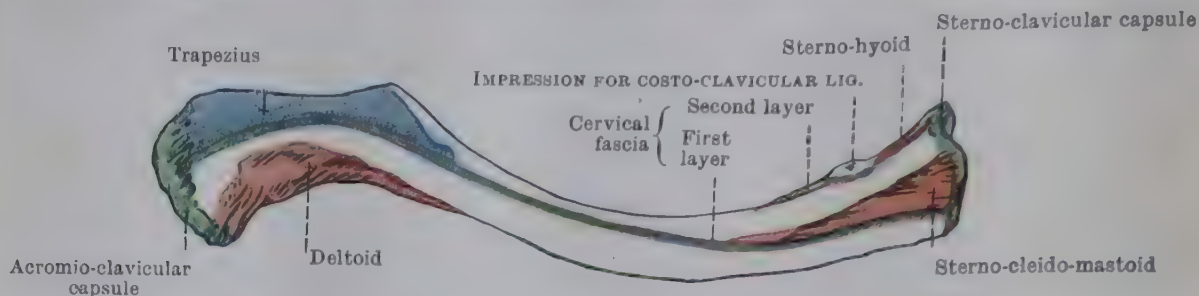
SUPERIOR ASPECT OF RIGHT CLAVICLE.
